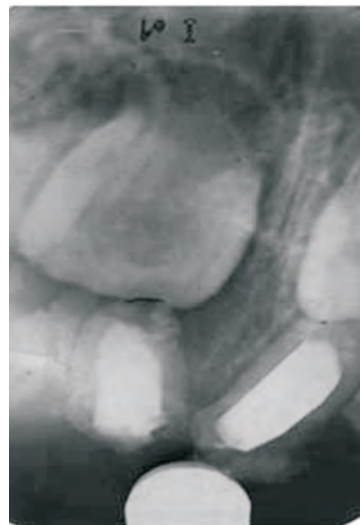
Post-operative radiograph with obturated 51 and 61.
